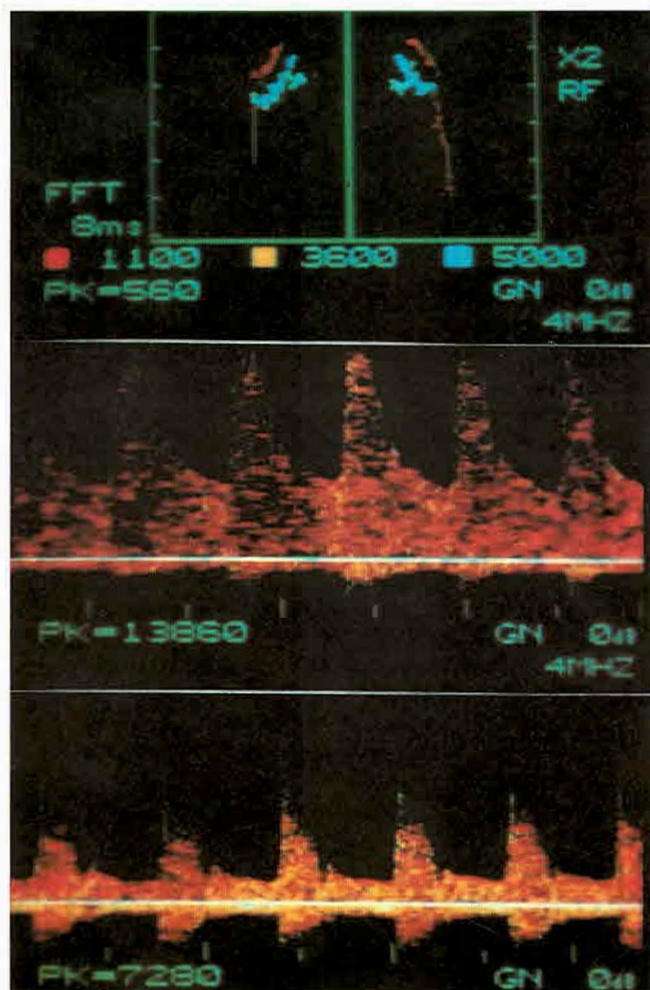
Study of carotid artery performed with the Dopplerechoflow-scan. Standard color coding for carotid scanning indicates severe stenosis of the right and left external carotid artery. A frequency analyzer is helpful in distinguishing between the internal and external carotid arteries.
